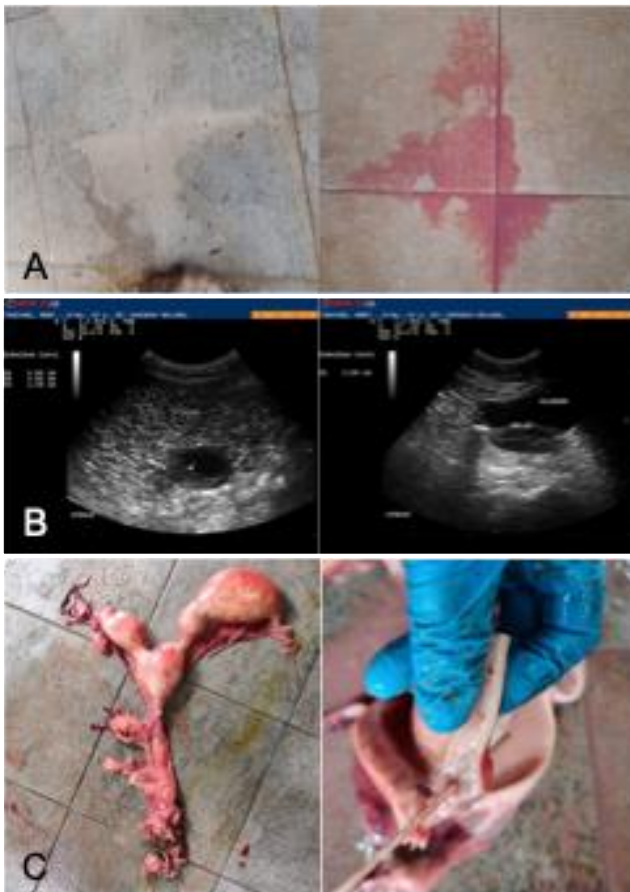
(A) Mucopurulent vulvular discharge in the night stall floor of Tanjung, a 17-year-old female Malayan tiger (*Panthera tigris jacksoni*) in captivity at the National Wildlife Rescue Center (NWRC), Malaysia; (B) Fluid-filled uterus confirmed by ultrasonography; (C) Uterus with pyometra and perforation of the uterus.
